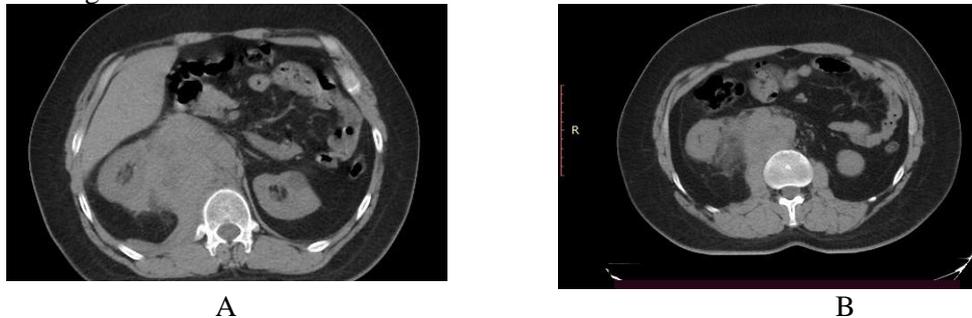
Retroperitoneal lymphoma, axial CT cuts of the abdomen reveals ill-defined soft tissue density mass seen at RT peri-spinal retroperitoneal space which cannot be separated from RT paravertebral muscle, the mass displacing the RT kidney upwards and outwards.....Q lymphomatous infiltrate
